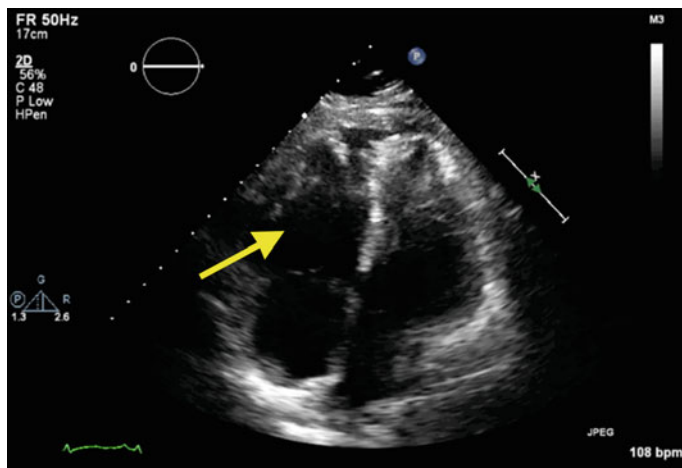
Apical four-chamber view in a patient with a dilated RV (yellow arrow) due to an acute pulmonary embolus
